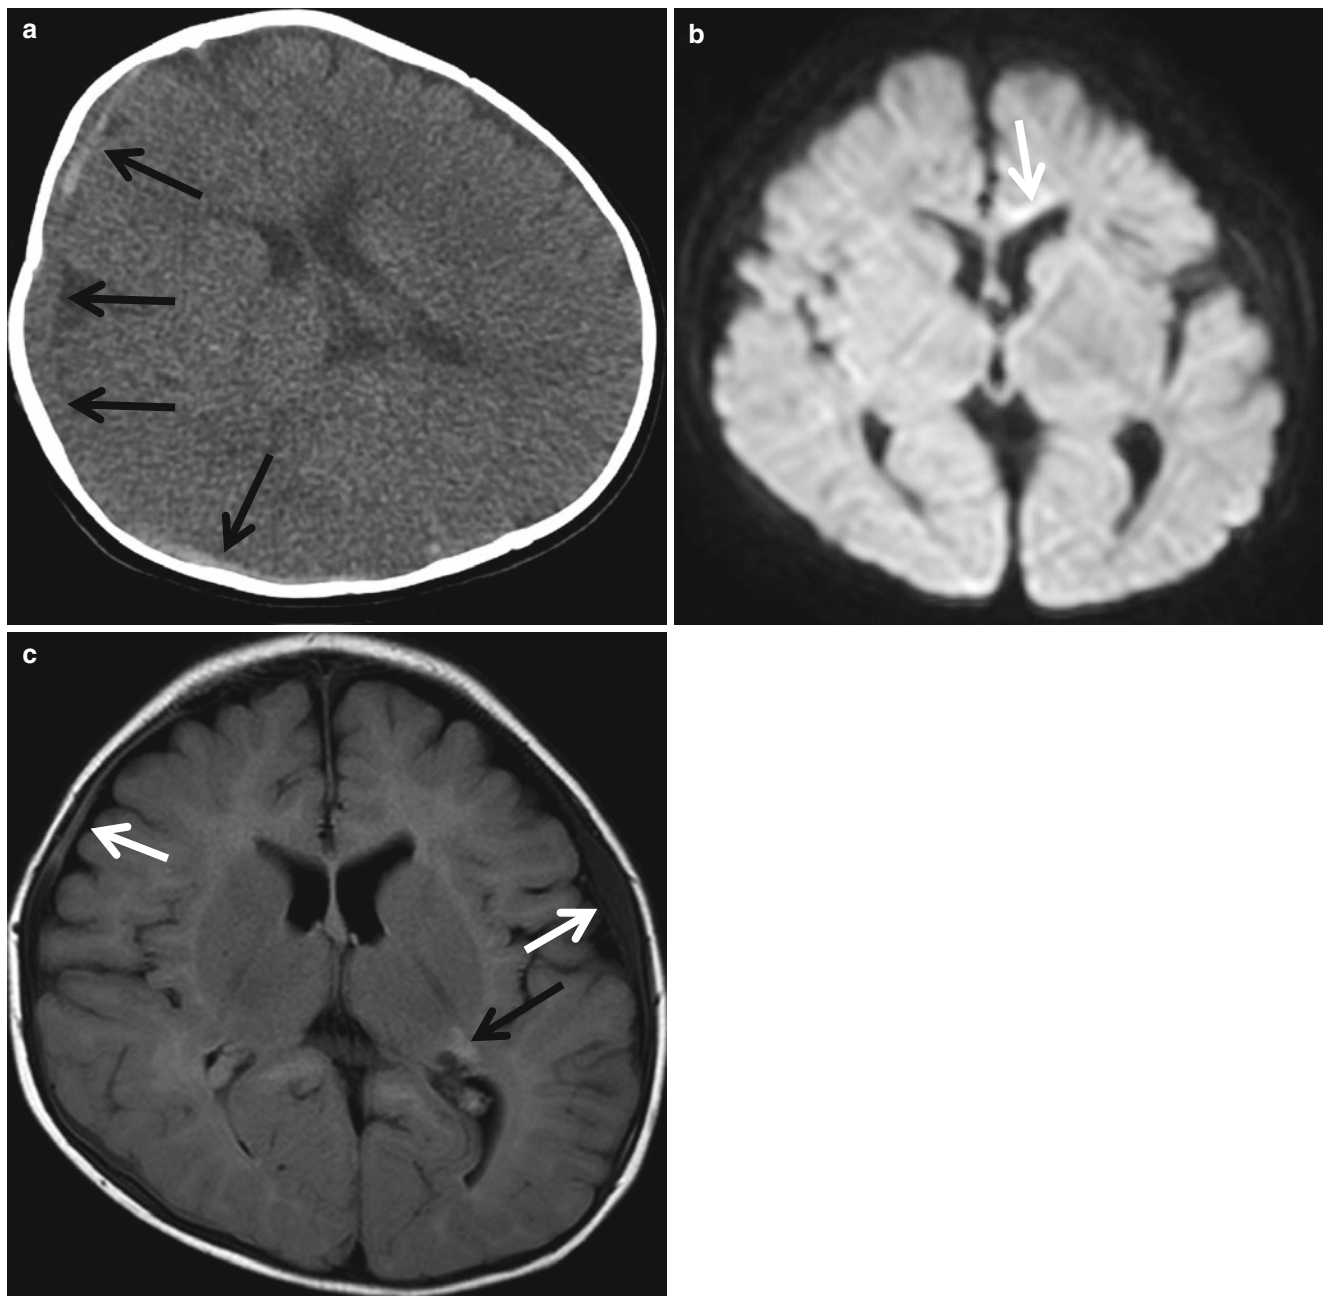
Multistage SDH and parenchymal injury in nonaccidental injury. (a) Precontrast CT shows small amount of SDH of mixed iso- and high attenuation (*arrows*). (b) Diffusion-weighted image obtained 1 month later shows slightly hyperintense lesion in the left frontal lobe
